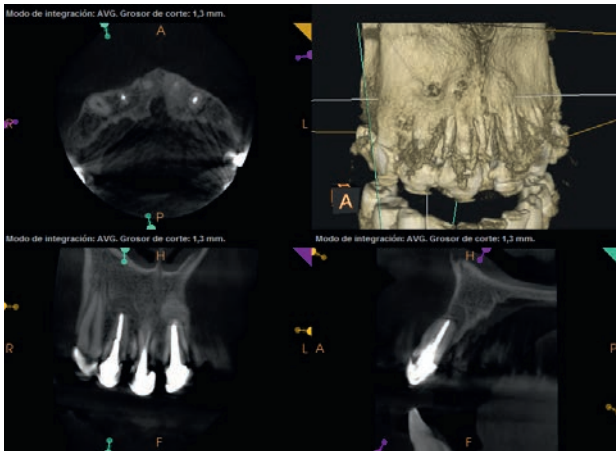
18 months control CBCT image of upper right lateral incisor after periapical microsurgery, showing complete healing of the previous periapical radiolucent lesion.
